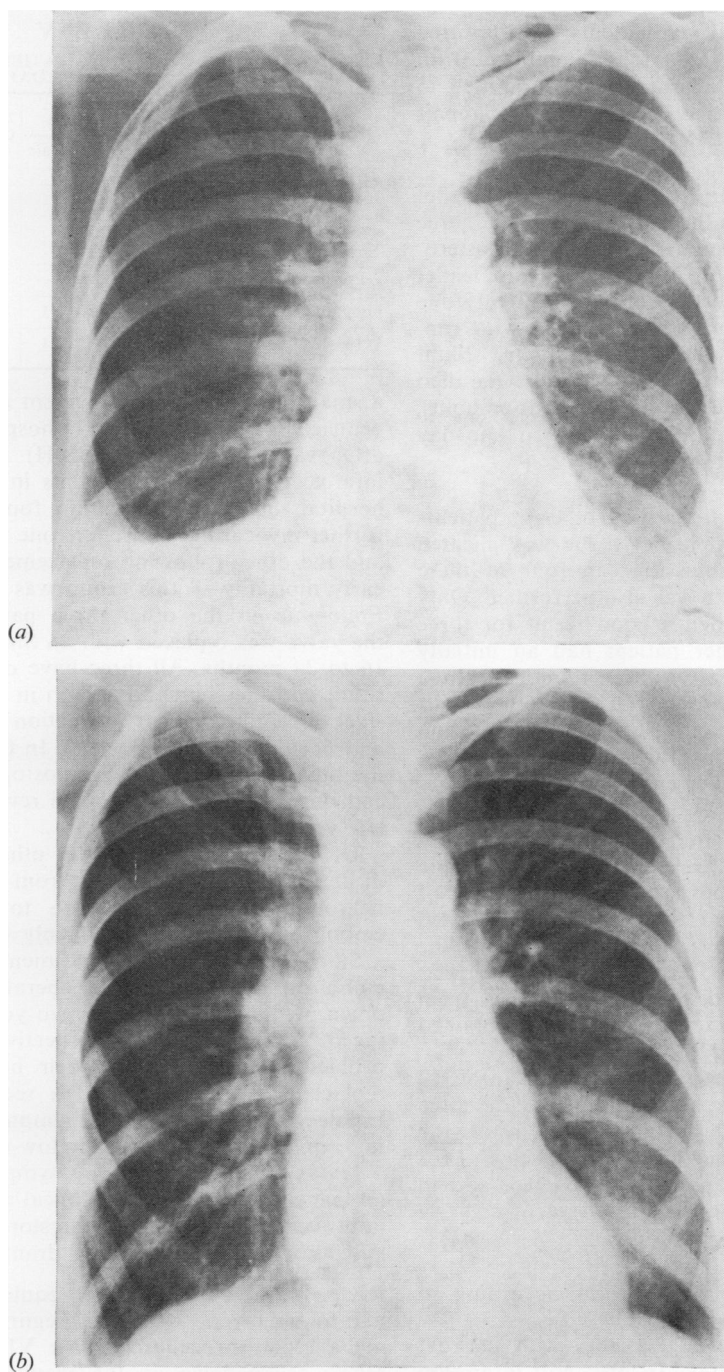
(a) *Preoperative chest radiograph two months after onset of symptoms in a patient (No. 6, Table IV) with ruptured chordae controlling the posterior leaflet;* (b) *four years after a successful repair by the plication technique.*
